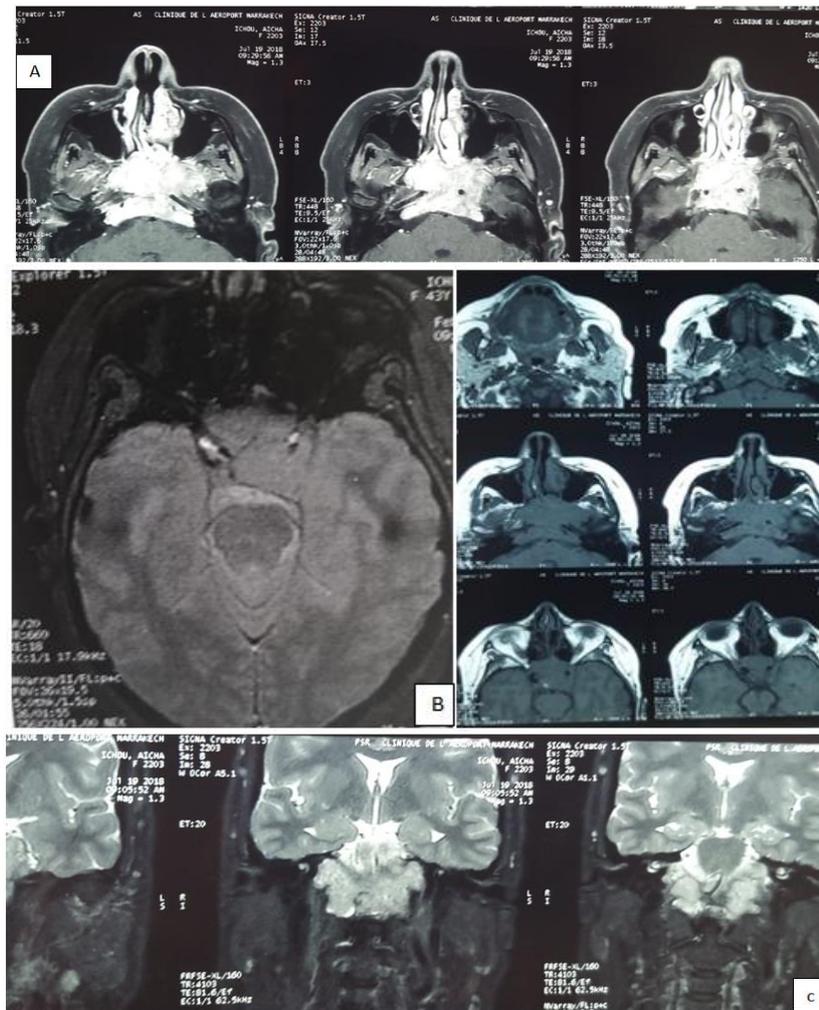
Preoperative magnetic resonance imaging with contrast, axial (a, b), and sagittal (c) sections, demonstrating contrast enhancing clivaltumor
